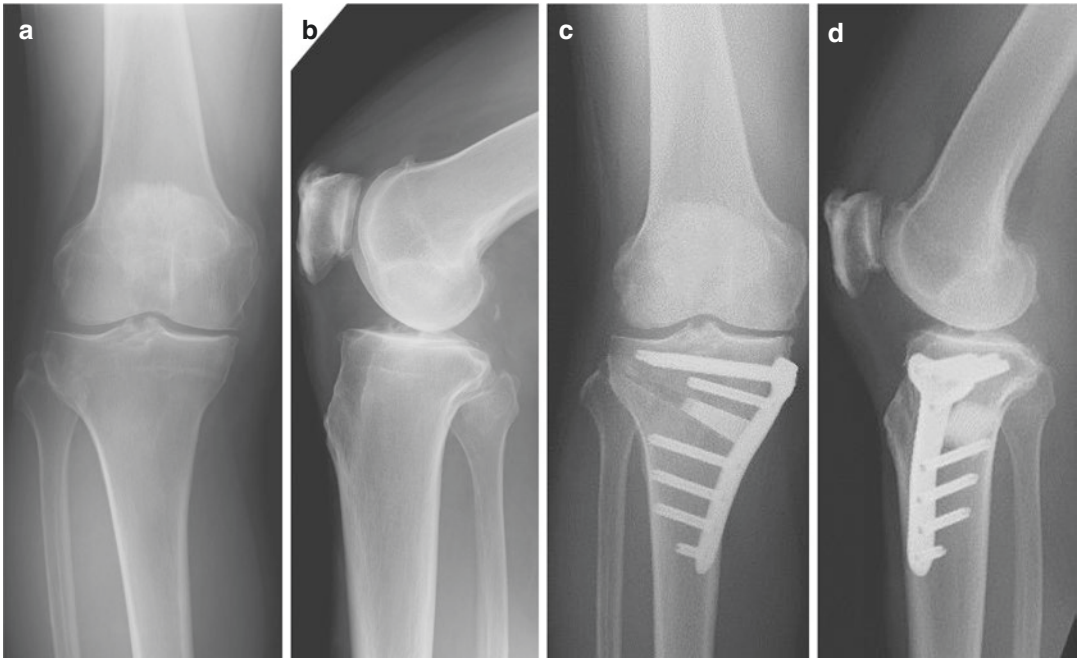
Pre and postoperative radiographs. (a) Preoperative antero-posterior view. (b) Preoperative lateral view. (c) Postoperative antero-posterior view. (d) Postoperative lateral view
